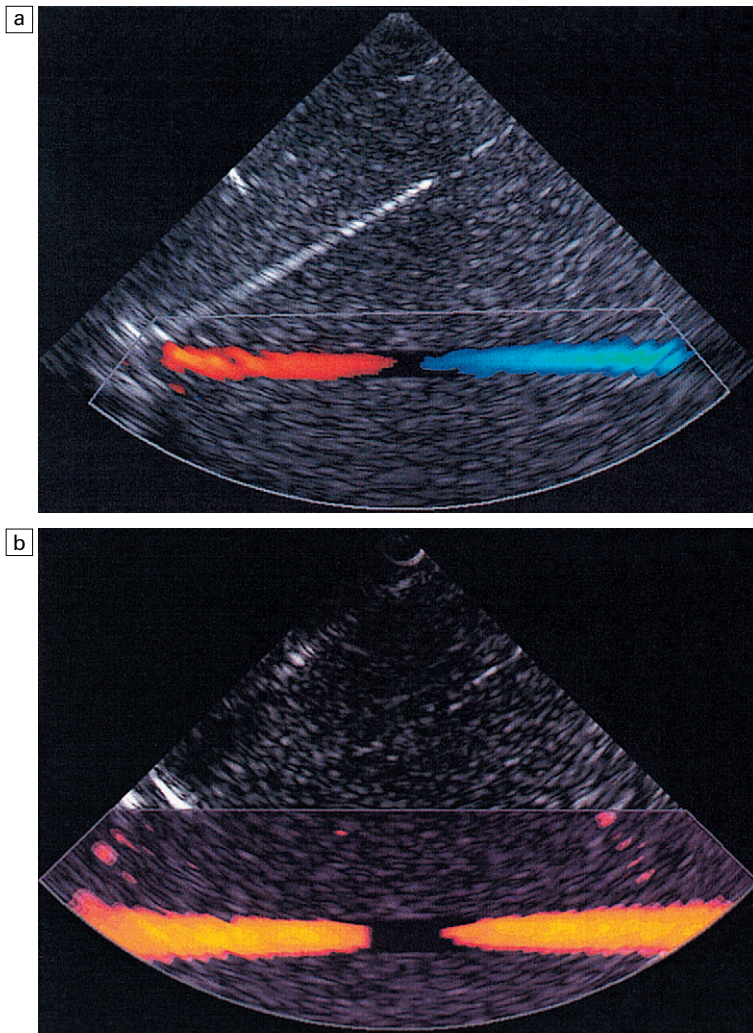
(a) Colour flow image of flow in a straight tube. When the flow velocity component is along the beam towards the transducer it is colour-coded red, when the component along the beam is away from the transducer it is coded blue. (b) Power Doppler image of flow in a straight tube. Direction of flow is not measured so it is not colour-coded.
